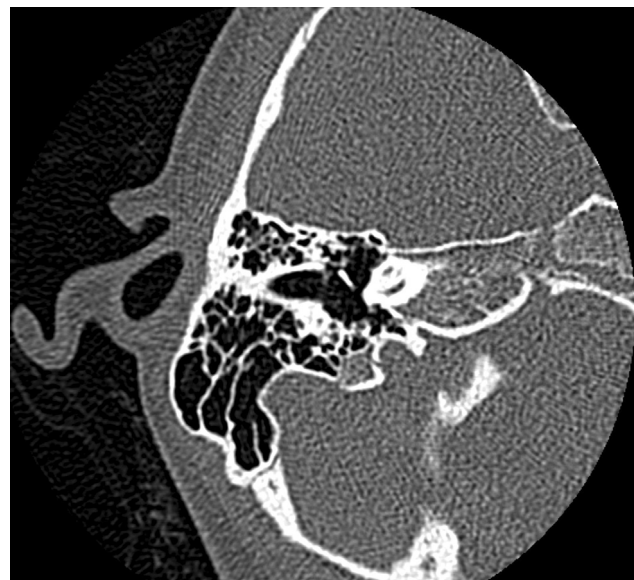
Preoperative CT temporal bone protocol. No evidence of bone remodeling or osseous involvement.
